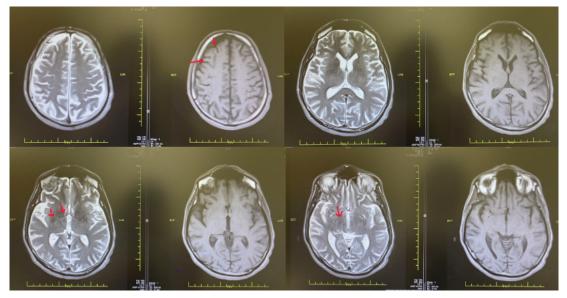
MRI T1 and T2 images of the patient showed mild iron deposition in the basal ganglia and cortical atrophy. (arrow)
